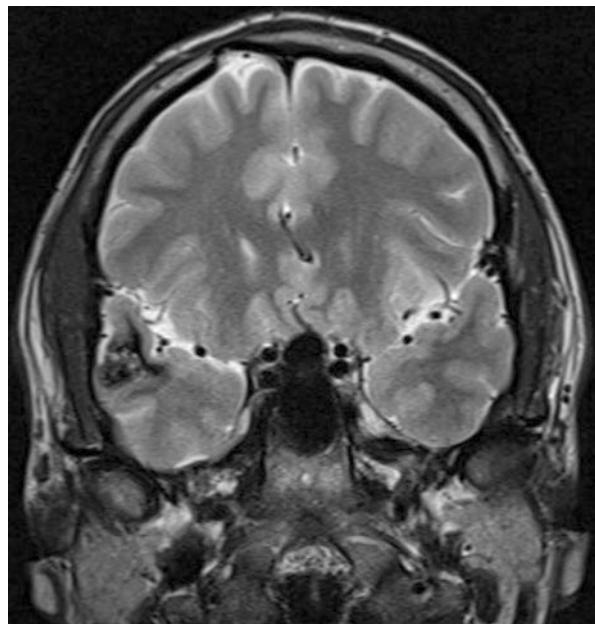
MRI axial T2-weighted images in a 32-year-old man with focal epilepsy. Note the large left inferior frontal lobe arteriovenous malformation. Images courtesy of Dr. Lilit Mnatsakanyan
